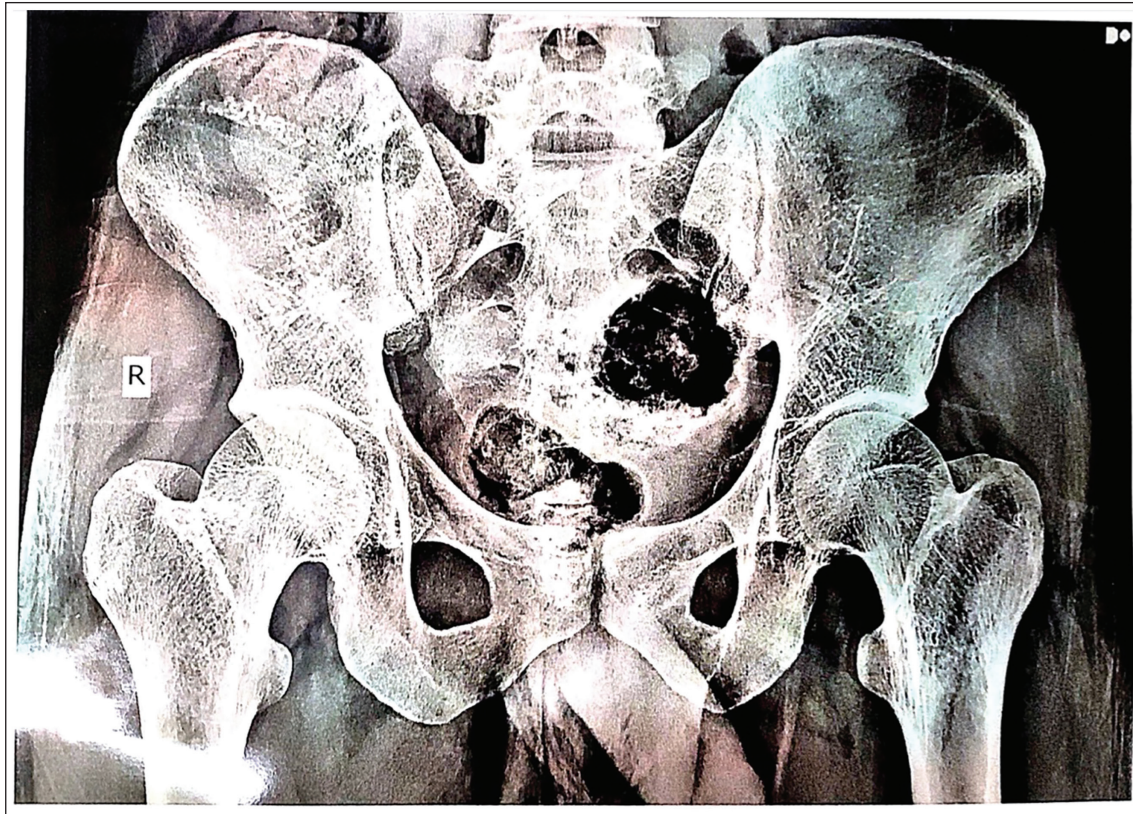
X-ray Hip Joint Shows Significant Osteoporotic Early Degenerative Changes.
